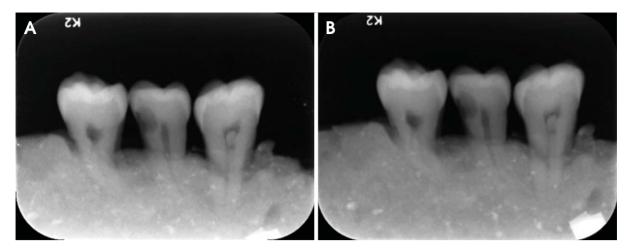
Digital radiographic images show the teeth radiographed with 60 kVp (A) and 70 kVp (B).
